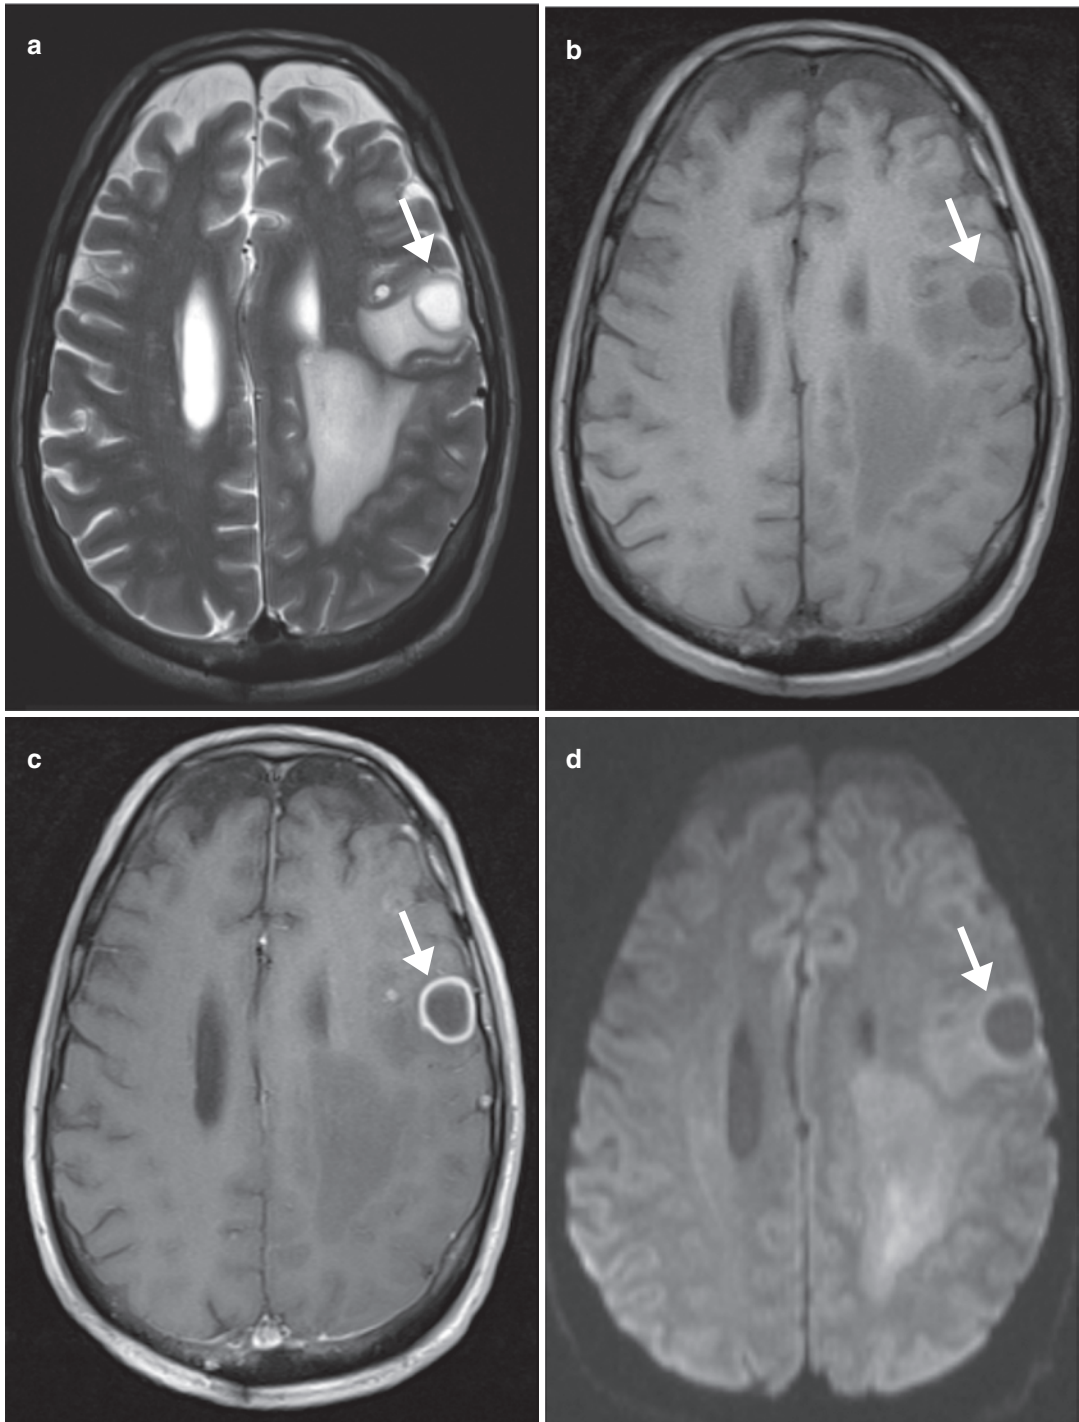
Cerebral parenchymal liquefied caseating tuberculoma. Axial (a) T2-W, (b) T1-W, (c) contrast-enhanced T1-W, and (d) diffusion-weighted MR images show a left frontal nodule (arrows) that is T2-hyperintense with a
